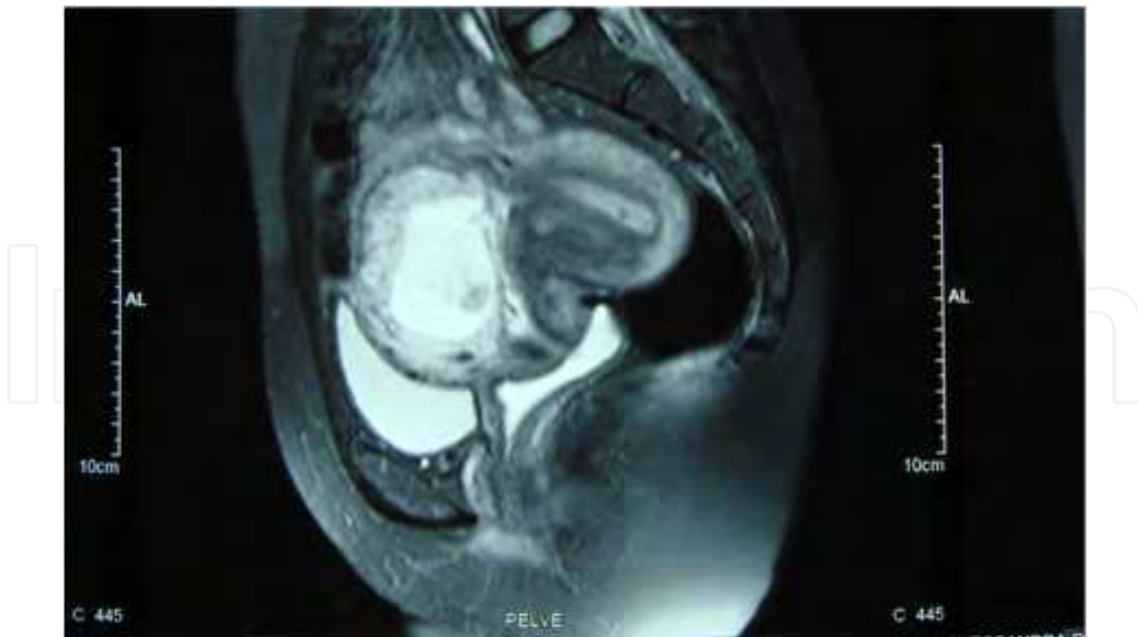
Magnetic resonance imaging of the same case (Elito, Camano, 2010a).
